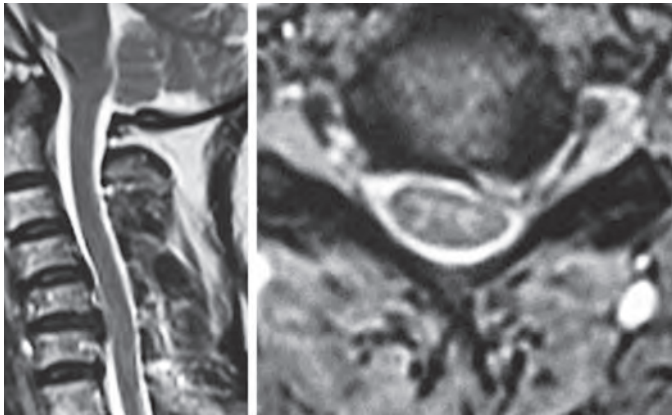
MRI showing loss of lordosis with anterior compression at C5/6 disc level, axial plane confirming the left lateral (foraminal) disc prolapse
